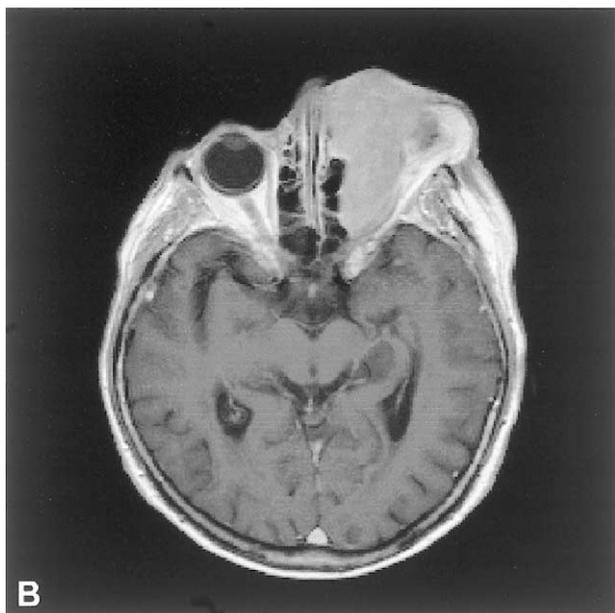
A:* Gross anterior and lateral displacement of the left eye of Case 2. *B:* Demonstration of the extent of tumor infiltration in the orbit with compression of the nasal cavities on MRI.
